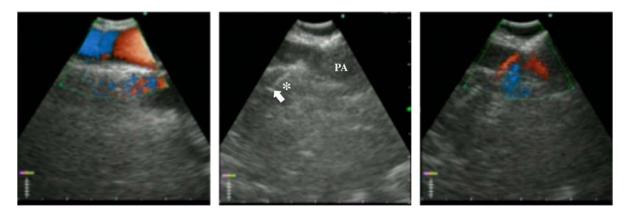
Endobronchial ultrasound view with Doppler enhancement before and during trans-PA needle aspiration in patient 6 (*lymph node station 5). The arrow indicates the tip of the needle. PA indicates pulmonary artery. *a*+
